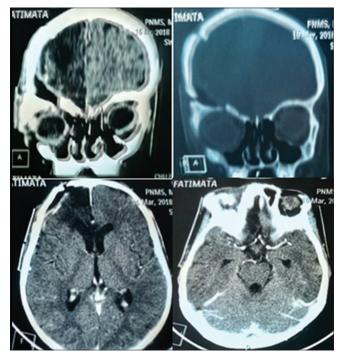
Postoperative brain computed tomography scan showing the resolution of intraorbital meningocele and exophthalmia.
